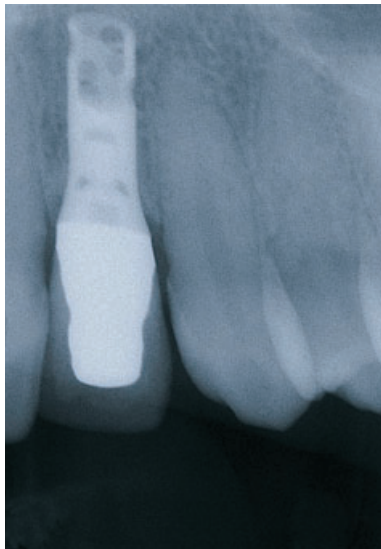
Ten-year post-operative radiograph of the maxillary left lateral single-tooth implant restoration.
